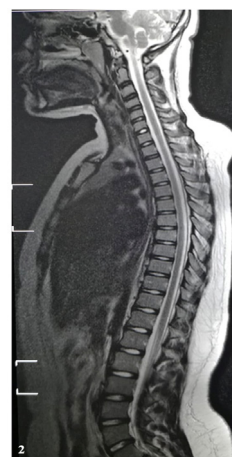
Whole-spine T2-weighted magnetic resonance imaging with contrast extensive epidural collection extending from T2 to T10. Spinal cord is compressed anteriorly with normal signal.
